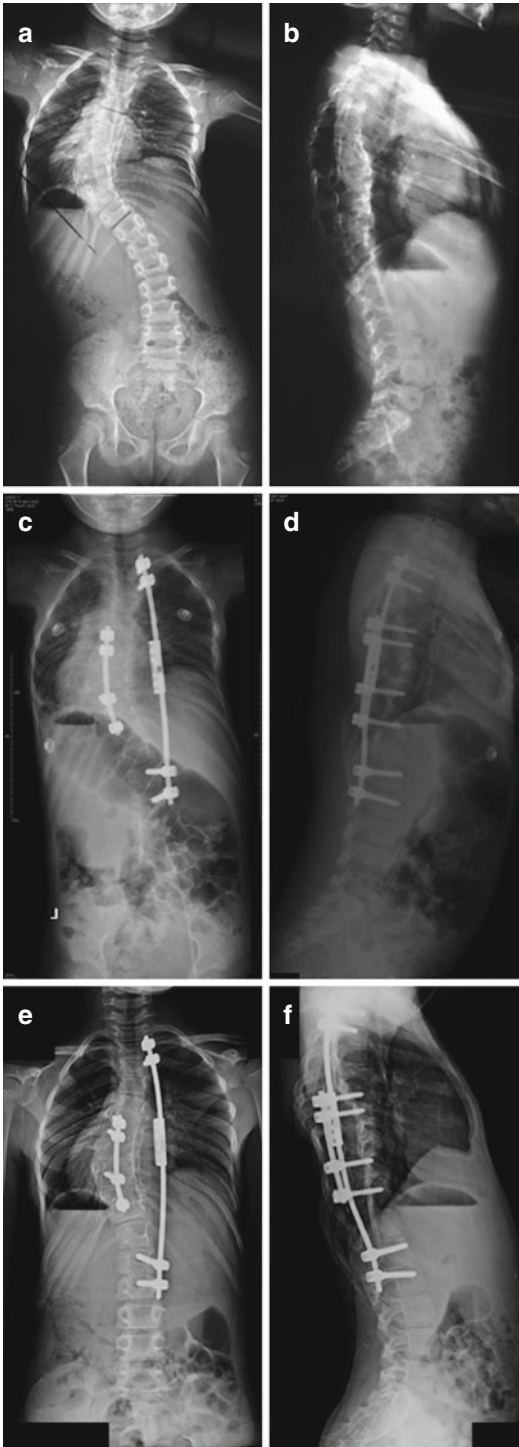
A four-year-old female with (a) 60° thoracic scoliosis and coronal off balance and (b) hypokyphotic sagittal alignment underwent an instrumented convex growth arrest with concave distraction. Postoperative radiographs show that (c) coronal balance was achieved with substantial curve correction (40°), and (d) there appears to be a positive sagittal balance. At 2-year follow-up, the patient showed (e) 2 cm growth of the T1–S1 segment of the spine and further correction of the coronal deformity to 30°. The sagittal balance and alignment seems minimally changed from the preoperative radiograph (f)
